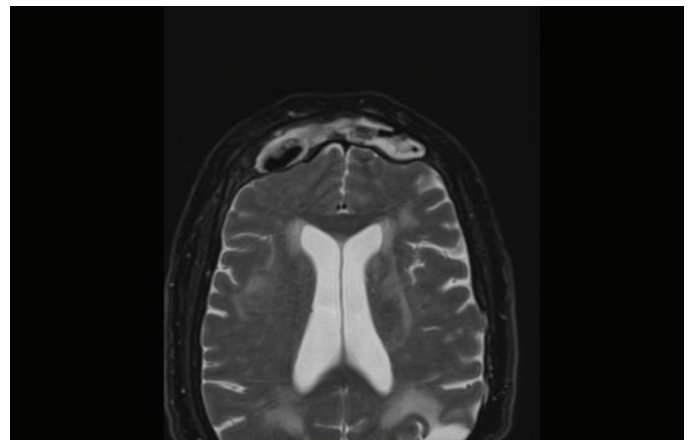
MRI T2 + fat saturation weighted imaging sequence showing a frontal sinus mass with a predominant hyperintense sign
